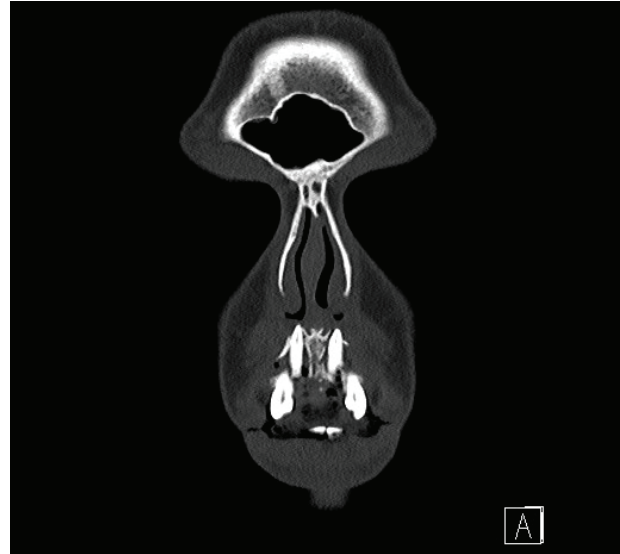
Coronal CBCT views showing the position of the maxillary central incisors
